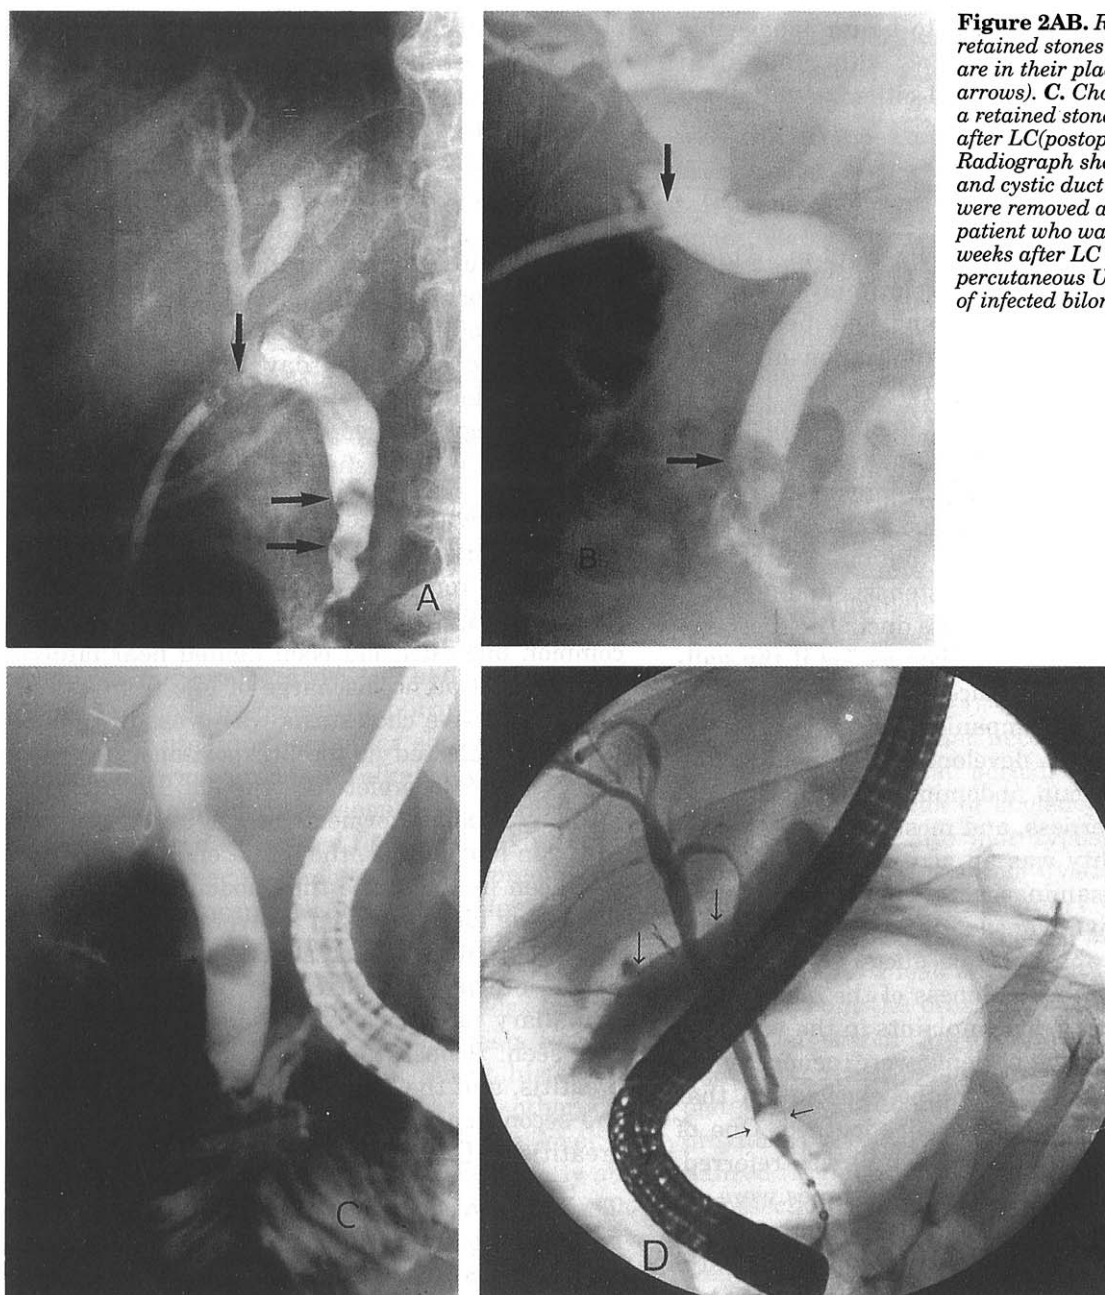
Figure 2AB. Radiographs show retained stones after OC. T-tubes are in their places (vertical arrows). C. Cholangiogram shows a retained stone measuring 1.2cm after LC(postop 5th day). D. Radiograph shows retained stone and cystic duct leak: All stones were removed after ES. This last patient who was referred two weeks after LC required percutaneous US-guided drainage of infected bilomas as well.
